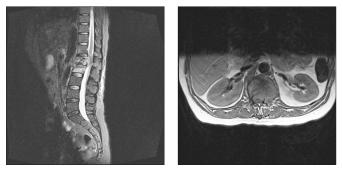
Sagittal T2 and axial T1 MRI imagining demonstrating epidural and vertebral body abscess formation with spinal cord compression. The anterior involvement of the adjacent segments with spread of the infection below the anterior longitudinal ligament is characteristic of spinal TB.
